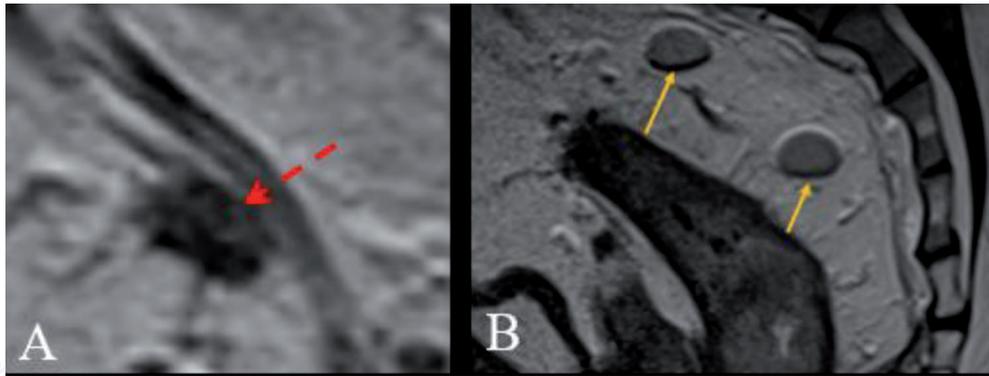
Lymph nodes of same size (4 mm) but with totally different morphology in MRI. A. Lymph node metastasis in a patient with rectal cancer. Note the typical aspect of malign lymph nodes: inhomogeneous signal; irregular border with spikes (red arrow). B. Benign (reactive) nodes (arrows), characterized by homogeneous signal and well-defined borders on the background of anal fistula (no cancer!). Source: F. Bauer, Radiology Kaufbeuren.
